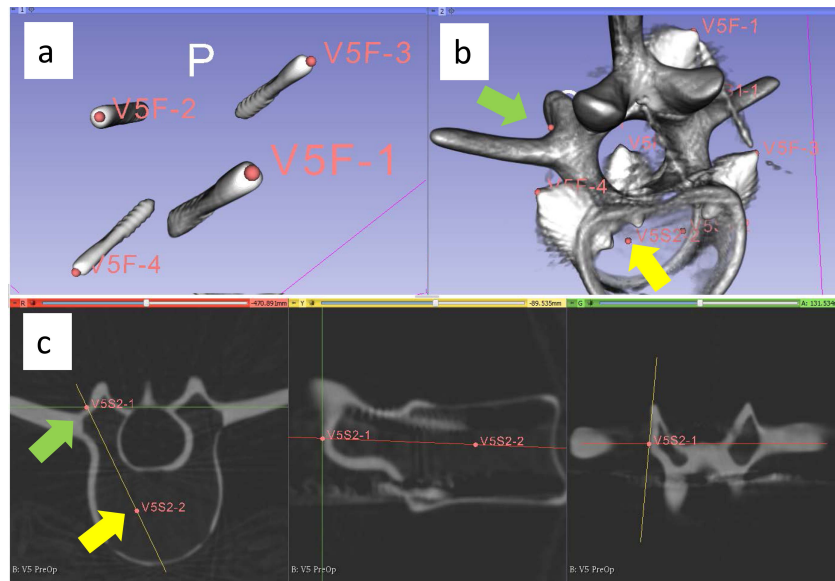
Pre-operative C-arm CT image of synthetic vertebra displayed on surgical planning workstation. Reformatted planar views were used to identify both the fiducial marker tips and the screw path plan (entry and destination points). Point locations were verified using volume renderings. (a) Fiducial markers shown in a volume rendering. (b) Screw entry (green arrow) and destination (yellow arrow) points shown in a volume rendering (windowed to visualize the vertebra). (c) Reformatted multiplanar views showing a screw entry (green arrow) and destination points (yellow arrow).
